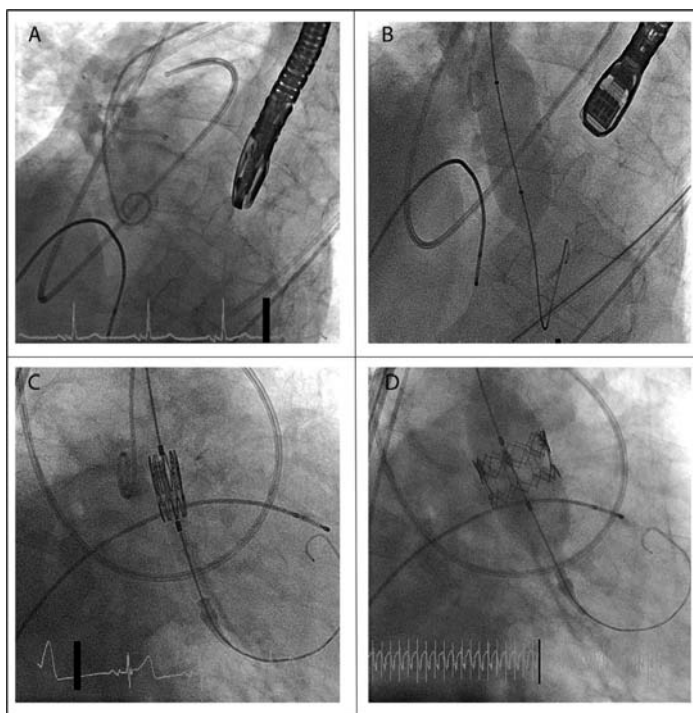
Transcatheter aortic valve replacement. Panel A demonstrates proper positioning of various catheters and devices for valve replacement: a transesophageal echocardiography probe in the esophagus, a Swan-Ganz catheter in the pulmonary artery, a pigtail catheter in the aortic root, AL-1 diagnostic catheter in the ascending aorta (prior to valve crossing), and a temporary pacemaker wire in the right ventricle. Panel B demonstrates aortic valvuloplasty being performed using a standard balloon. Panel C demonstrates proper positioning of the crimped Edwards SAPIEN prosthesis across the aortic valve. Panel D demonstrates the deployment of the valve using balloon inflation after initiation of rapid pacing.
